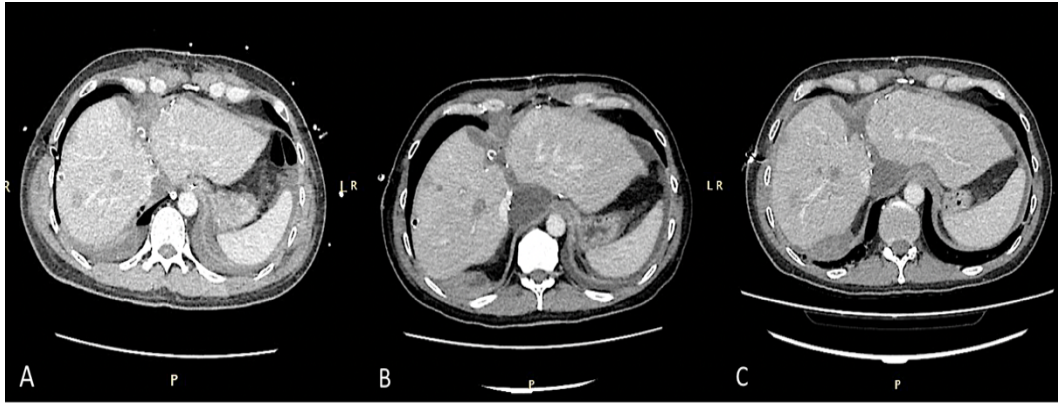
CT-scan after surgery A)POD1 B)POD7 C)POD14
